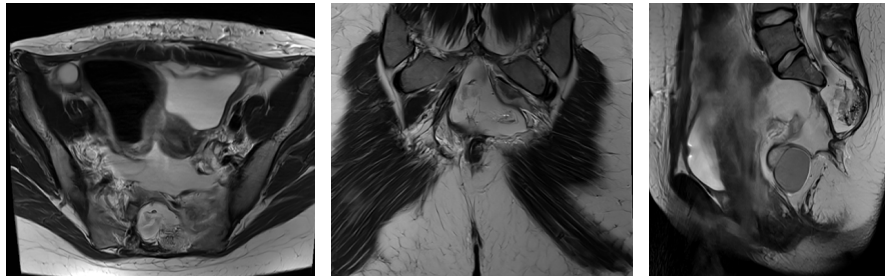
Postoperative MRI MRI imaging, T2 sequence in three planes axial, coronal and sagittal (from left to right).
